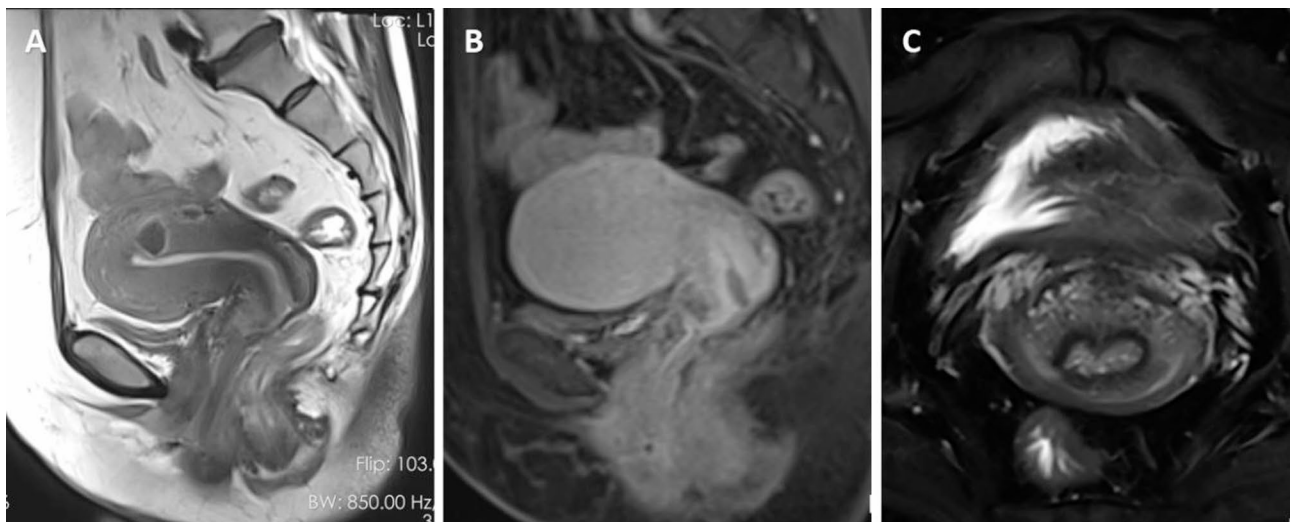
Preoperative magnetic resonance imaging. (A) Preoperative T2-weighted sagittal imaging. (B) Preoperative T1-weighted contrast-enhanced sagittal imaging. (C) Preoperative fat-suppressed T2-weighted axial imaging
